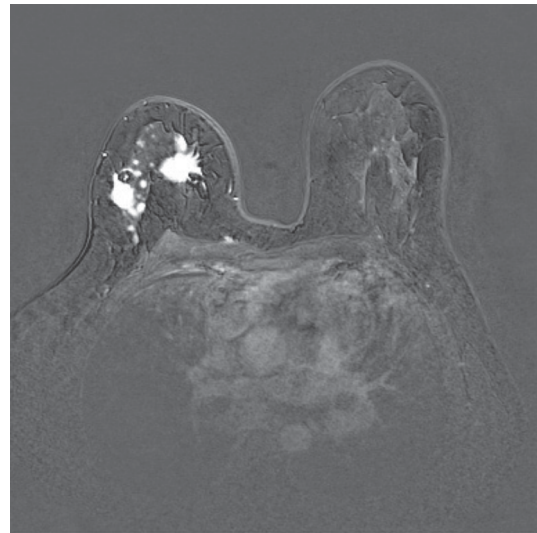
Breast MRI, T1 with contrast subtraction axial image, showing multiple irregular shaped enhancing masses in central and outer part of right breast
